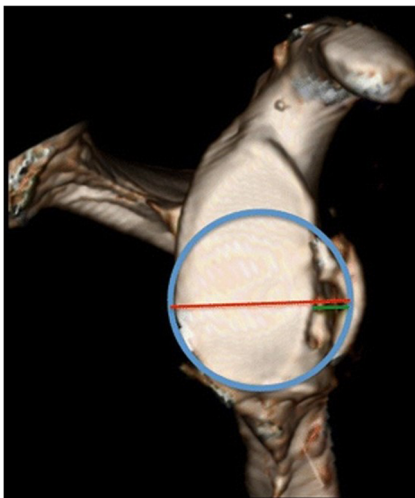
3D-MRI of glenoid, en face view, demonstrating the best-fit circle method of quantifying glenoid bone loss. (Reproduced, with permission, from Gyftopoulos S, Beltran LS, et al. use of 3D MR reconstructions in the evaluation of glenoid bone loss: a clinical study. *Skeletal Radiol.* 2014 Feb;43(2):213–8)
